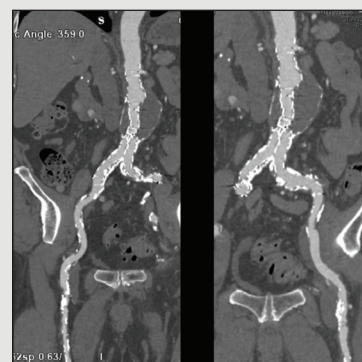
Postoperative CTA with patent EVAR and no evidence of endoleak. Patent right limb (left side) and patent left limb (right side).
